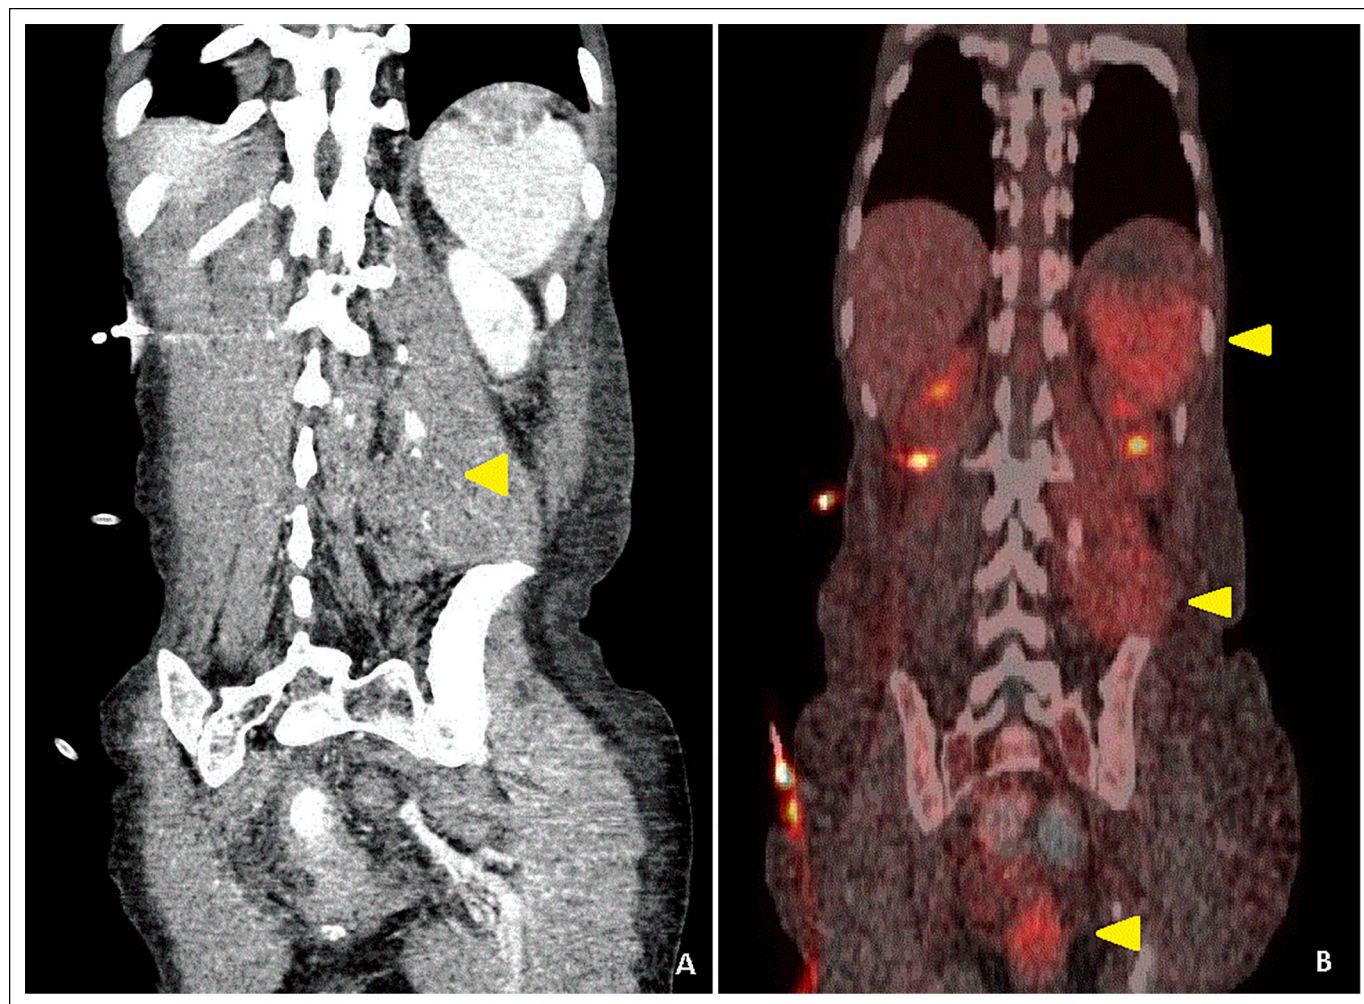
(A) CT with intravenous contrast demonstrating marked expansion of the left iliopsoas musculature (arrow) and (B) positron emission tomography (maximum intensity projection) demonstrating metabolically active mass at the level of the pylorus, bilateral thigh masses, hypermetabolic mediastinal adenopathy, and bilateral pulmonary nodules. CT, computed tomography.
